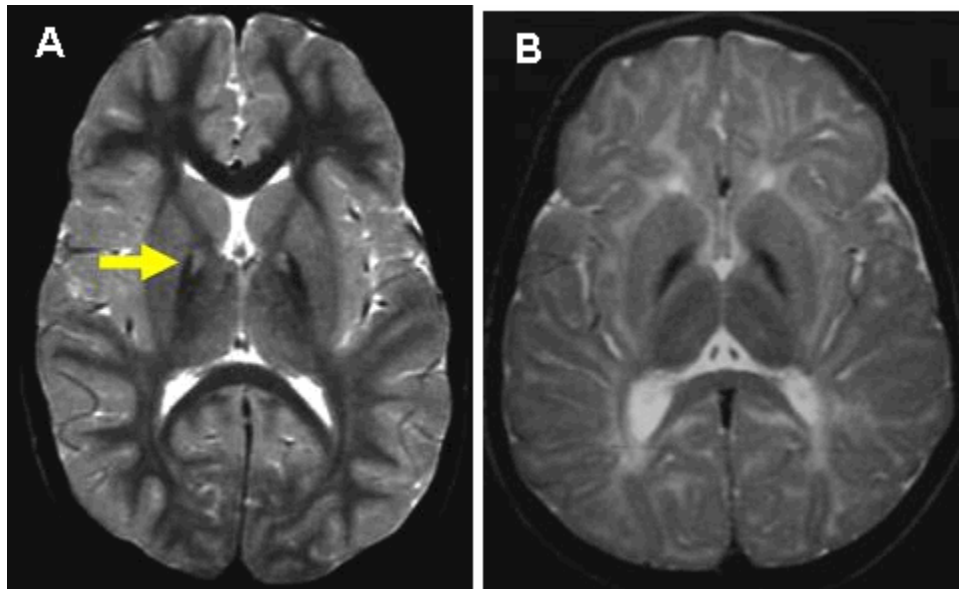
T₂-weighted brain MRI of PKAN (A) and non-PKAN NBIA (B)
